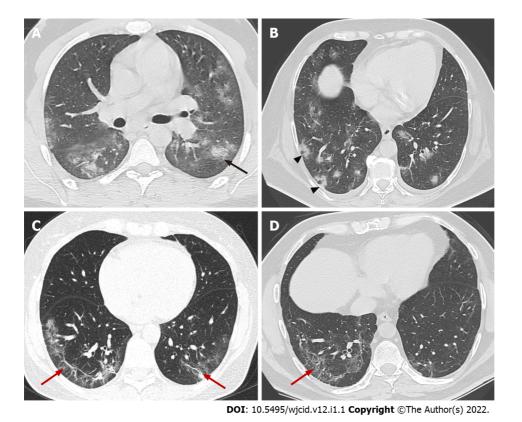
Axial computed tomography images demonstrate features seen in organizing pneumonia. A: Ground-glass opacities (GGO) surrounding small area of consolidation, "halo sign" (black arrow); B: Central GGO surrounded by denser consolidation of crescentic shape, "reverse halo sign" (arrowheads); C and D: Architectural distortion with interstitial thickening and irregular fibrous bands (red arrows).
